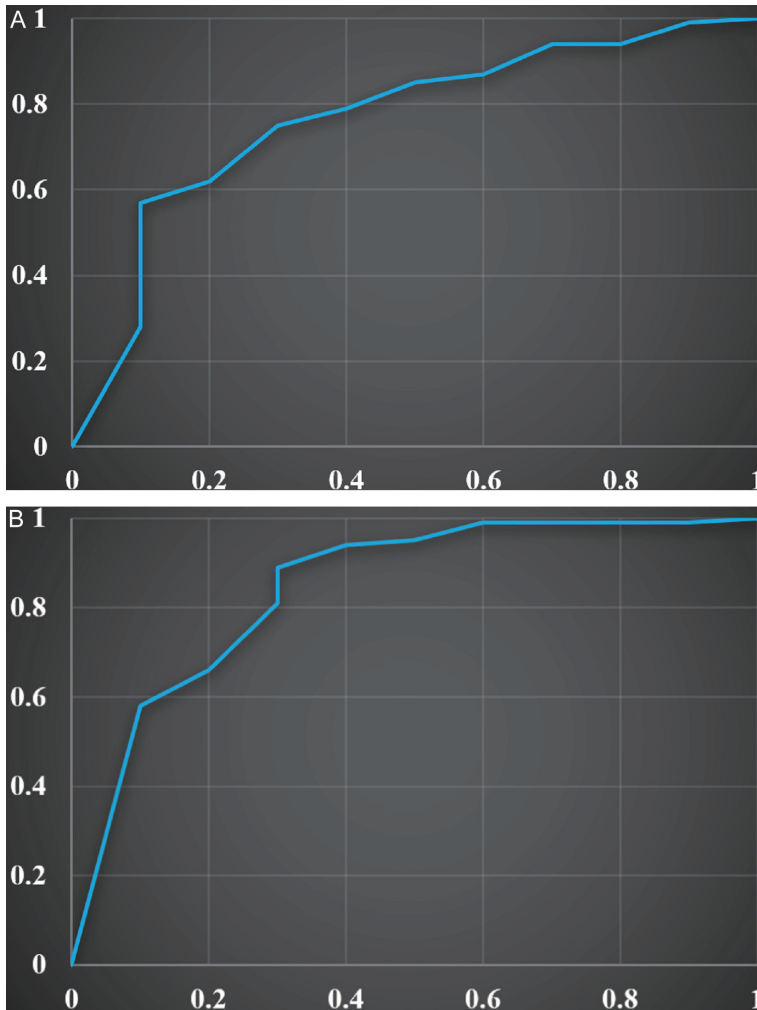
Predictive performance of the DCE-MRI and mammography models for breast tumor malignancy. A: Mammography model; B: DCE-MRI model.
